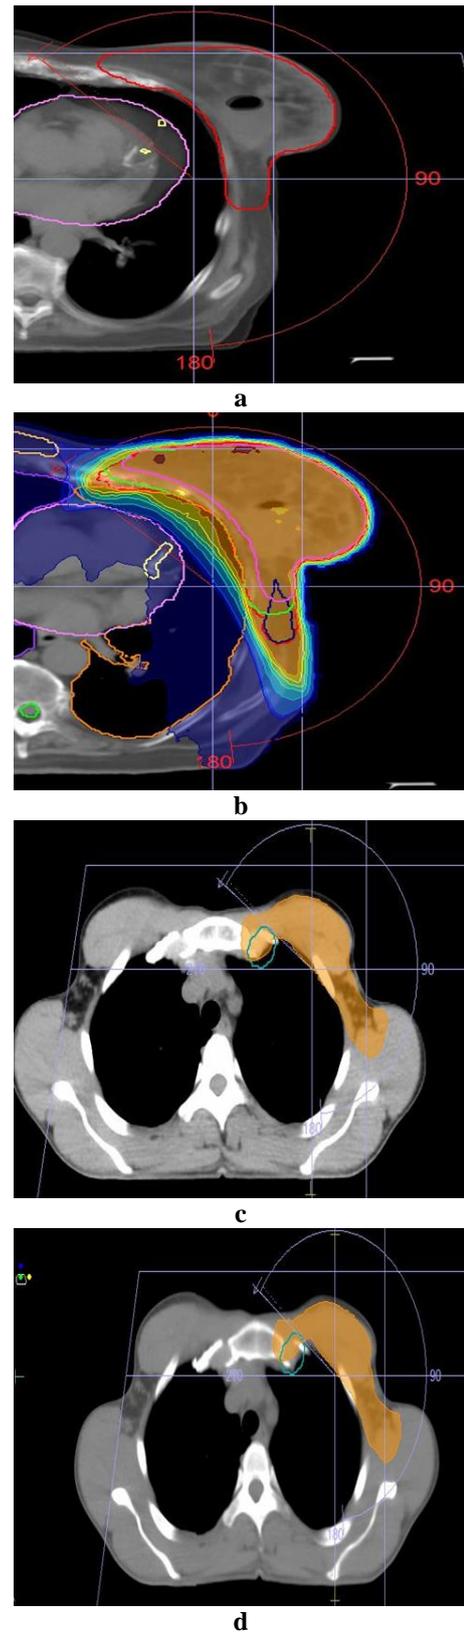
a) Axial CT Diffusion image between PCT (white) and CBCT (gray) in case 3, showing the proximity of the cardiac position to the radiation field in the CBCT more than that in PC, b) Dose distribution in the same CBCT explaining more heart exposure to the dose of radiation, c) IMC coverage in the PCT of Case 4 d) Decrease of the IMC coverage in the CBCT of Case 4.
